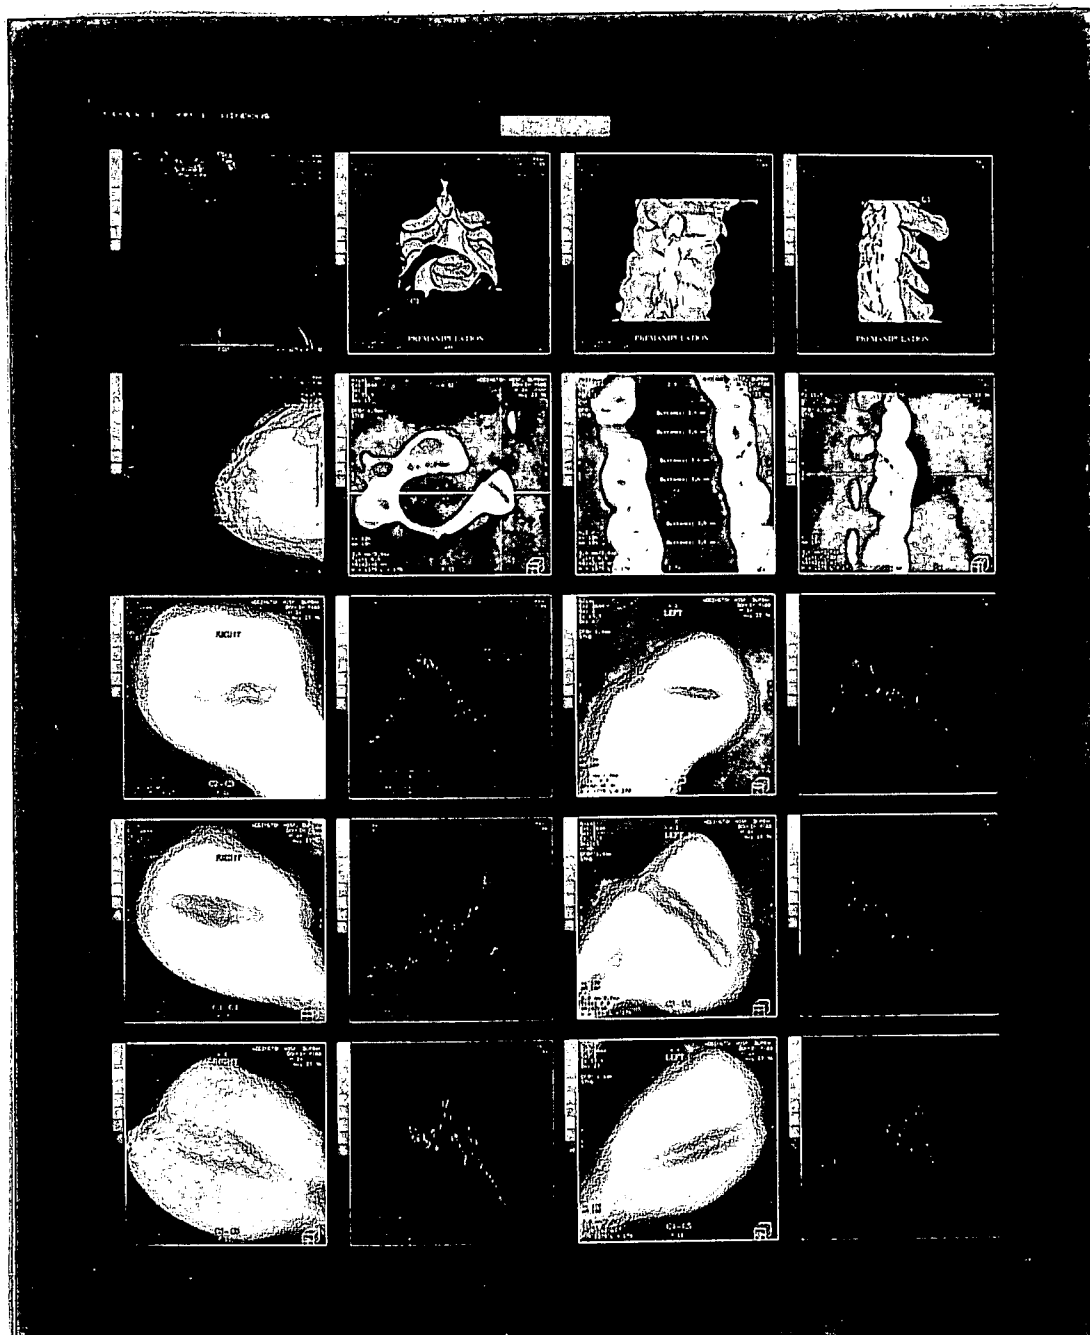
Experiment 5 : Pre-manipulation + 8kg traction CT scan.
